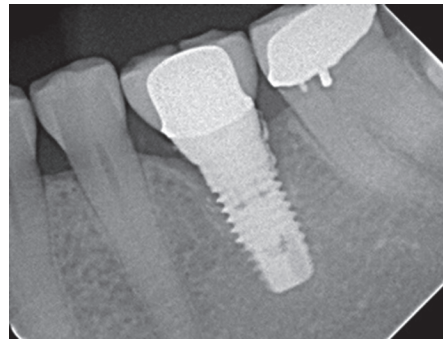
Radiograph showing retained cement on the distal surface of the implant and associated bone loss. The excess cement was later removed under an open flap procedure.
